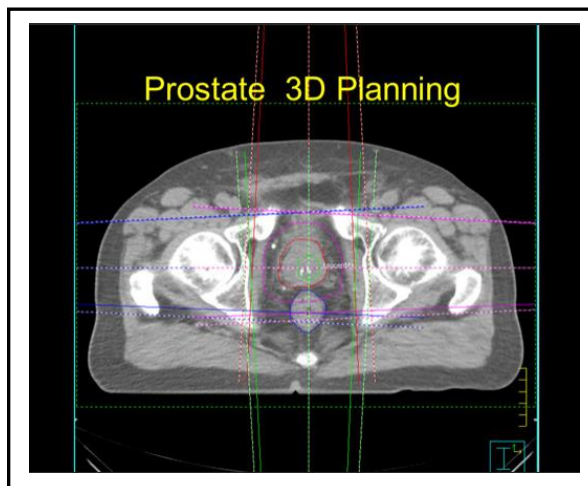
An example of one slice of computed tomography (CT) image for 3D planning of prostate cancer treatment [56]. The beams are conformal with the use of jaws alone but the tumour, healthy tissue and other organ can be clearly seen with the CT images
